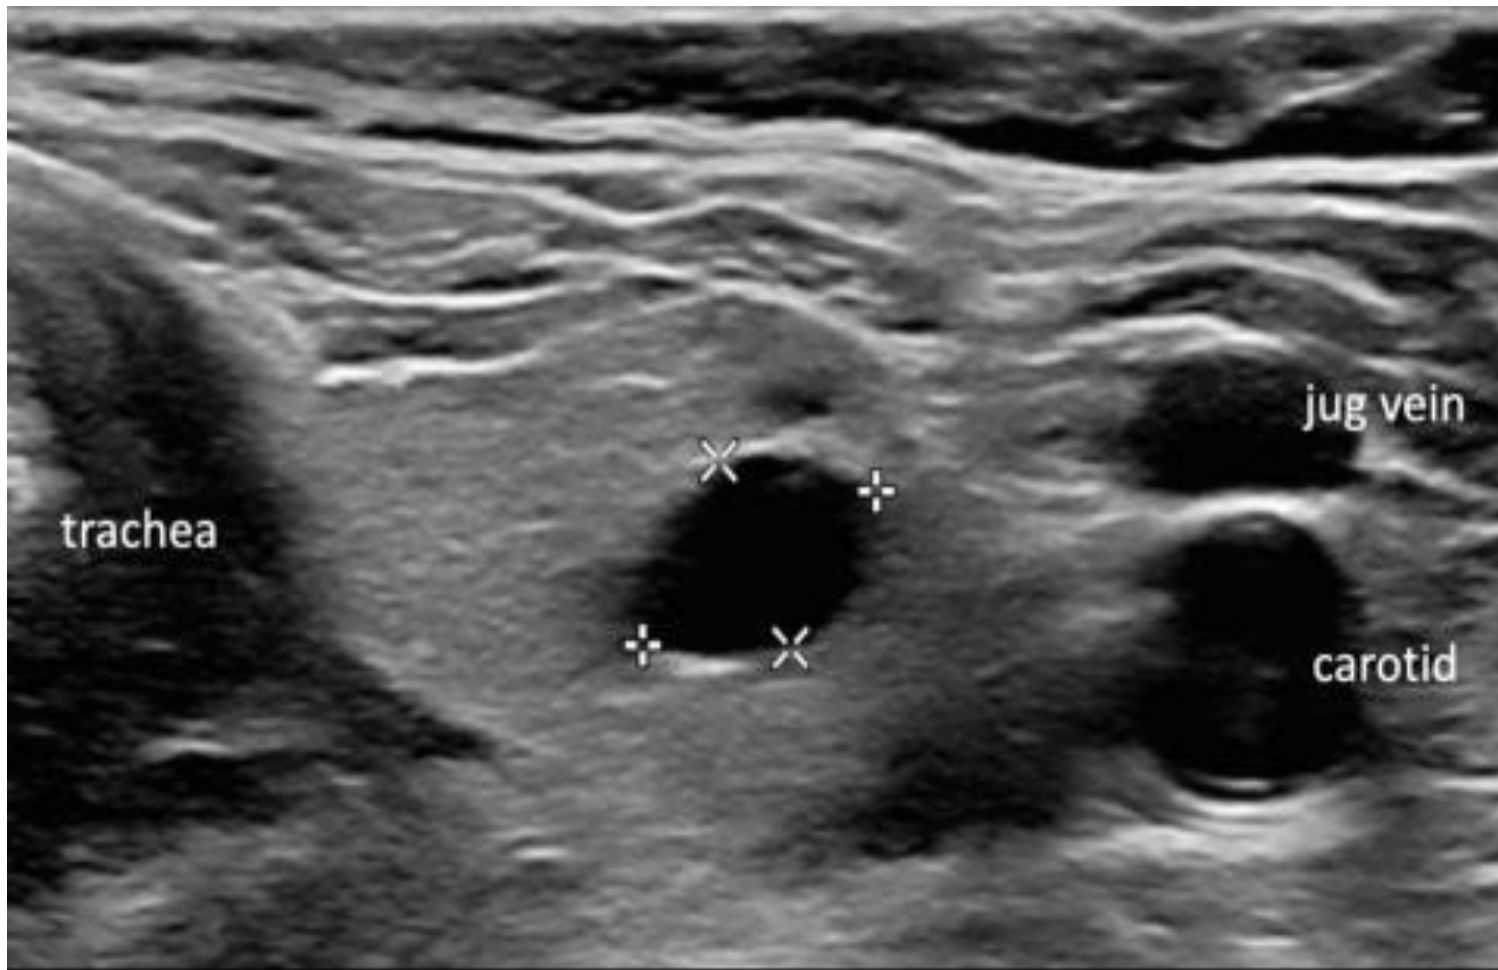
ATA nodule sonographic patterns and risk of malignancy.
